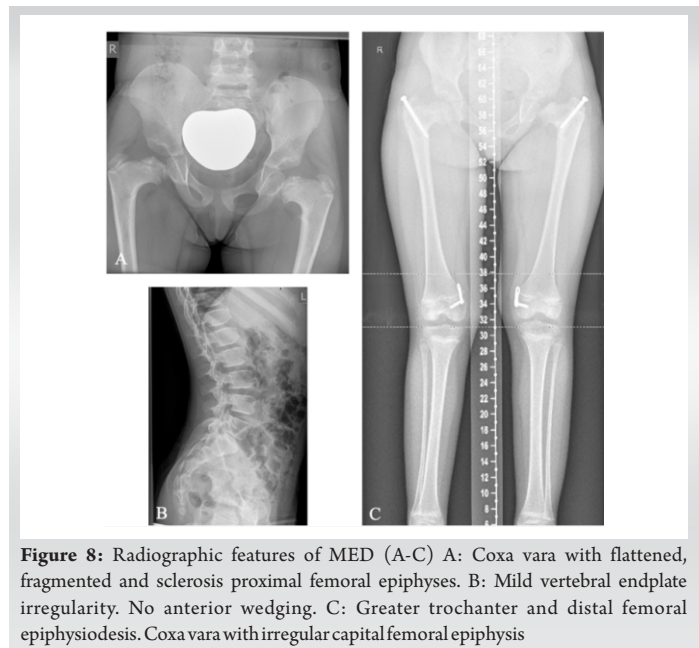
Radiographic features of MED (A-C) A: Coxa vara with flattened, fragmented and sclerosis proximal femoral epiphyses. B: Mild vertebral endplate irregularity. No anterior wedging. C: Greater trochanter and distal femoral epiphysiodesis. Coxa vara with irregular capital femoral epiphysis
